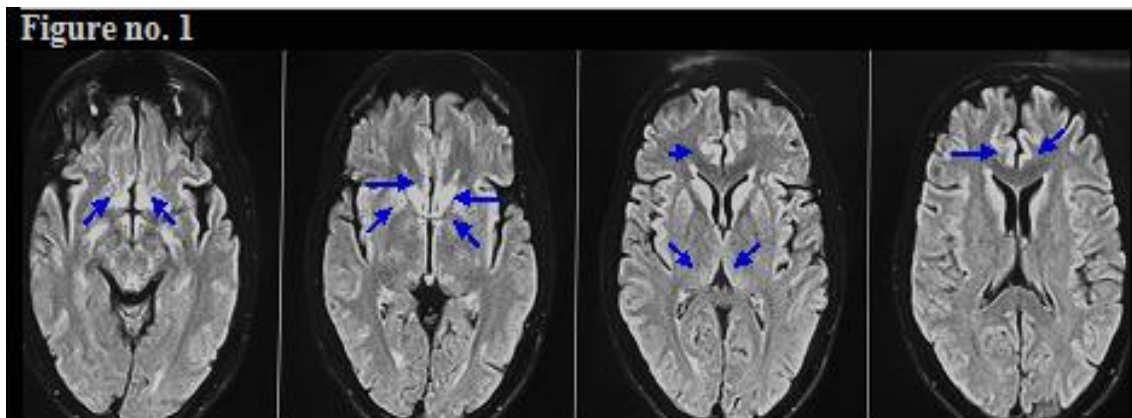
MRI brain on diffusion-weighted imaging (DWI) showed symmetrical bilateral increased signal intensities at the insula, cingulated cortex, bilateral dorso-medial thalami. Apparent diffusion coefficient (ADC) maps confirmed reduced diffusion
